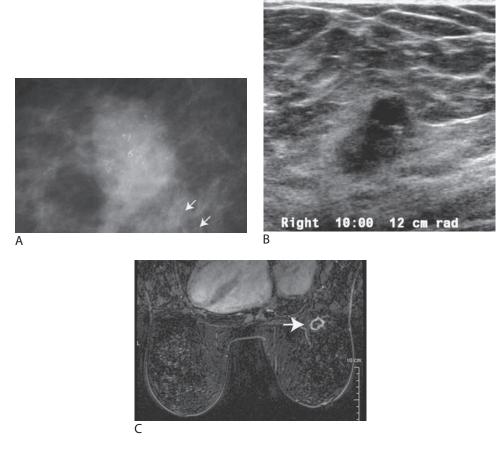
Invasive ductal carcinoma, not otherwise specified, poorly differentiated with associated DCIS, high nuclear grade with central necrosis. (A) Double spot compression magnification view ($1.8\times$). Oval mass with indistinct and lobulated margins associated with linear, casting type calcifications. Mass reflects invasive component; calcifications reflect intraductal component. On the magnification views, additional unsuspected calcifications are detected extending inferiorly from the mass (*arrows*). Even when there is an obvious finding, additional views are helpful in characterizing the extent of the disease. (B) Ultrasound demonstrates irregular, vertically oriented mass with high specular echoes characteristic of calcifications. Partial echogenic rim. (C) Magnetic resonance, subtraction image. Mass (*arrow*) with rim enhancement corresponding to the mammographic finding.
